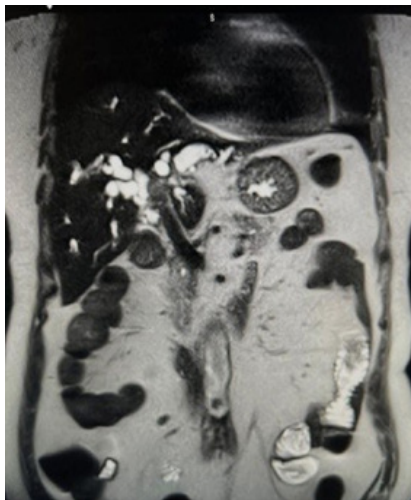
Coronal T2 weighted MRI demonstrating Hilar cholangiocarcinoma
